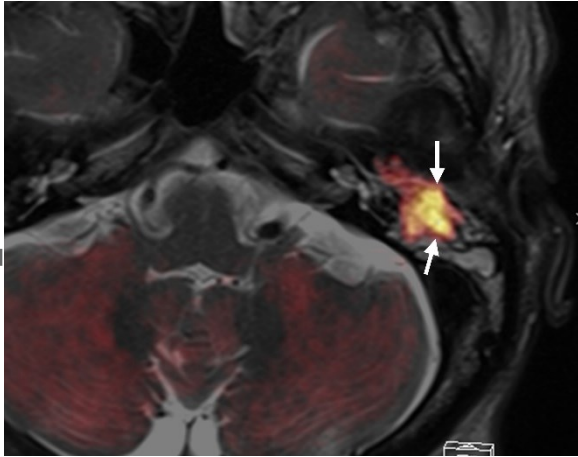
42-year-old male with a cholesteatoma of the left middle ear. The fusion image of diffusion-weighted imaging and T2-weighted image clearly shows the extent of mastoid extension of the cholesteatoma, which is easy to interpret (arrows).
